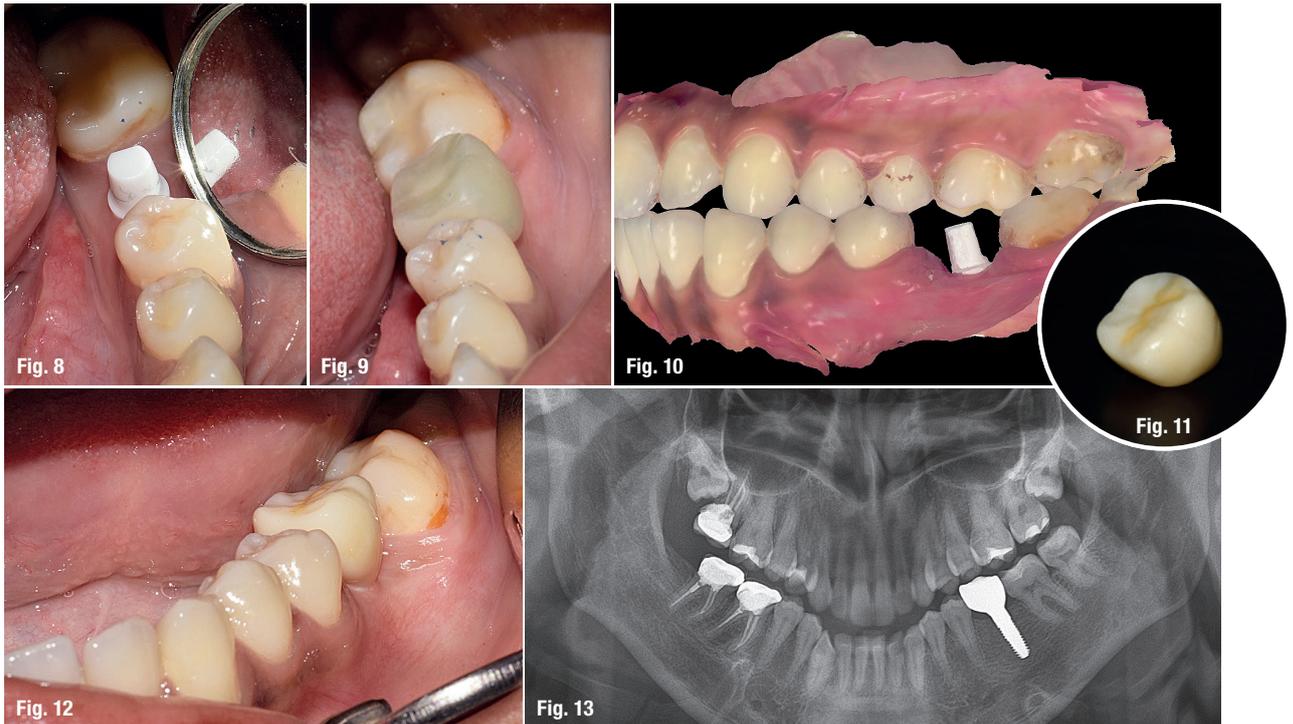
Provisional restoration. Fig. 9: Twelve weeks post-op. Fig. 10: Intra-oral scan. Fig. 11: Monolithic crown. Fig. 12: Final crown *in situ*. Fig. 13: Final radiograph.
